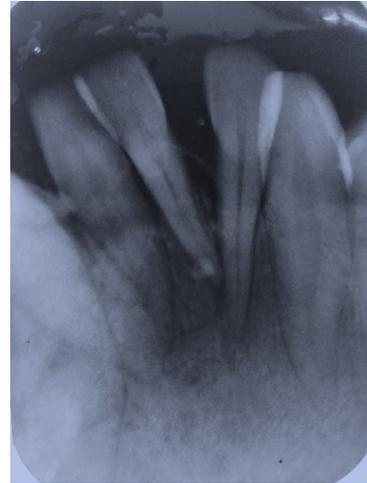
Intraoral periapical radiograph of 32, 31 41 and 42 region.
